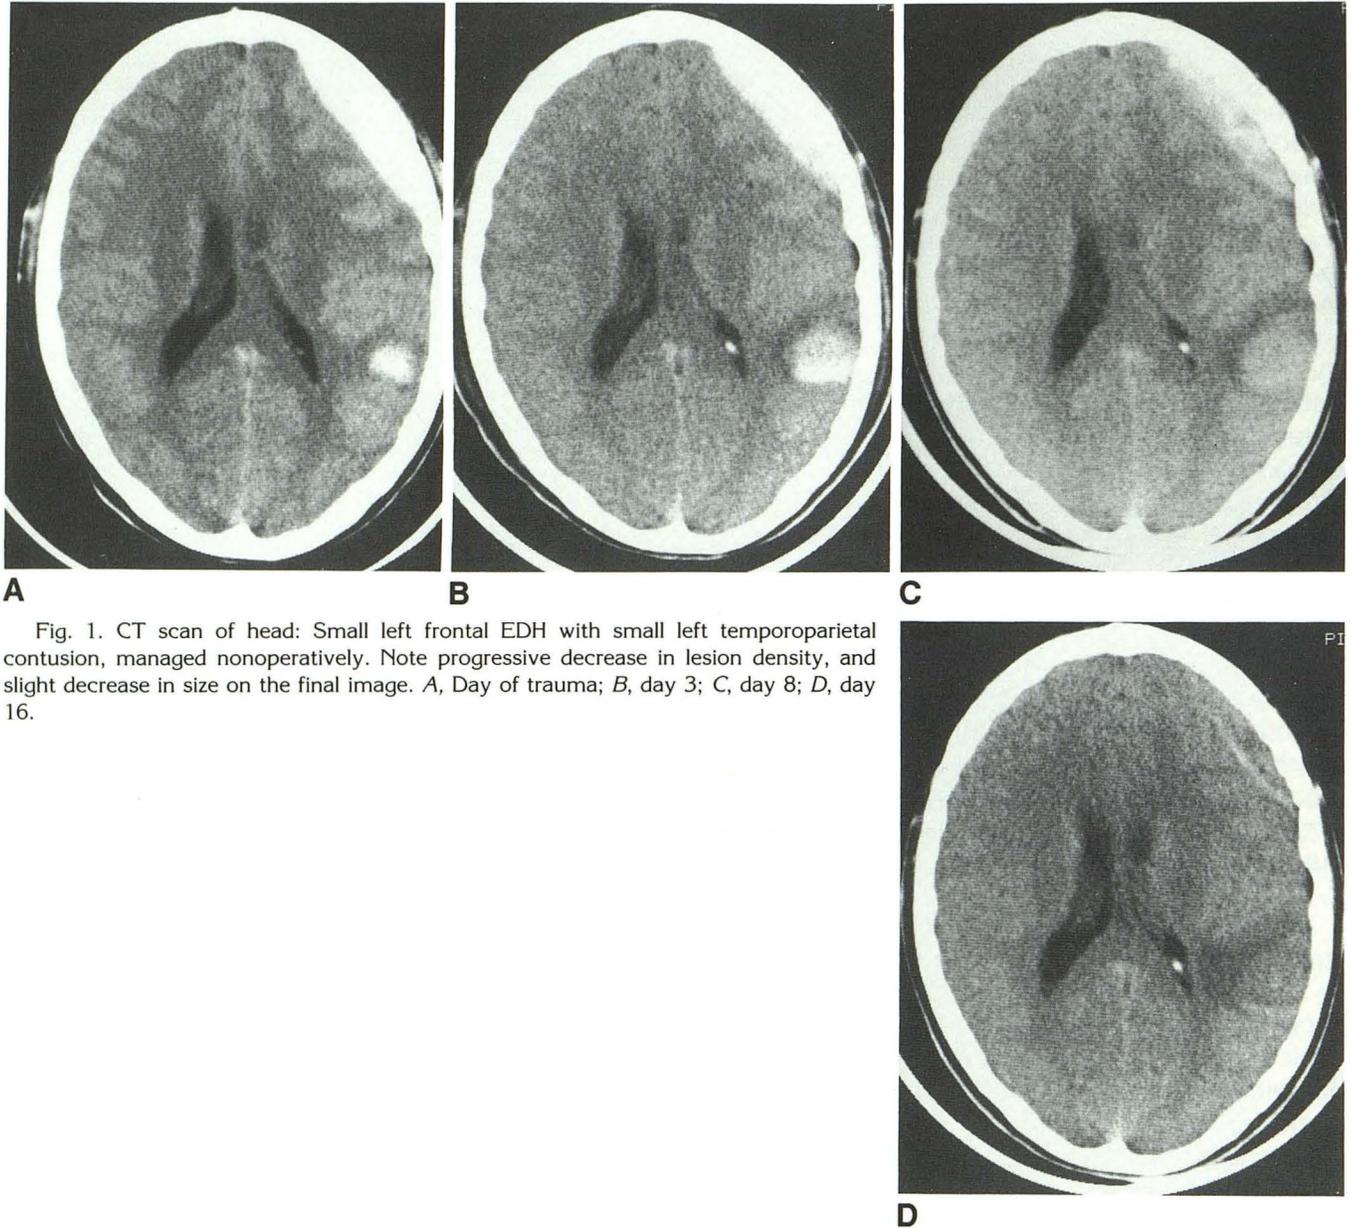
CT scan of head: Small left frontal EDH with small left temporoparietal contusion, managed nonoperatively. Note progressive decrease in lesion density, and slight decrease in size on the final image. A, Day of trauma; B, day 3; C, day 8; D, day 16.
